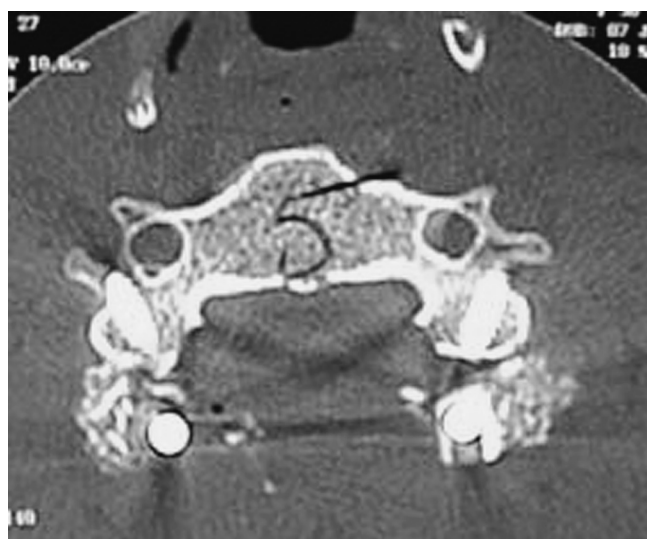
Postoperative axial CT scan showing typical bicorticate fixation. Note that the foramen transversarium is not breached as a result of the obliquity of the trajectory; typically, with a 14-mm screw, bicorticate fixation is attained.
